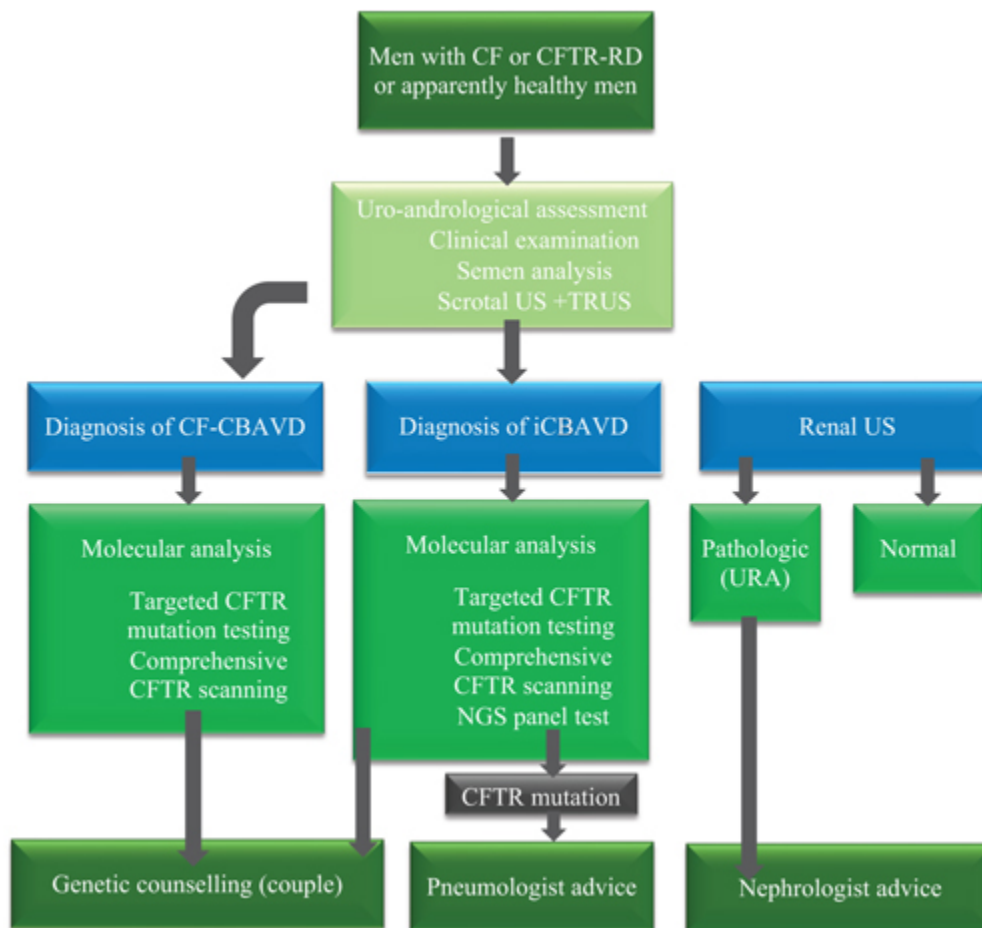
Management of men with congenital bilateral absence of the vas deferens (CBAVD). *Abbreviations:* CFTR, cystic fibrosis conductance regulator gene; iCBAVD, incomplete congenital bilateral absence of vas; US, ultrasound; TRUS, transrectal ultrasound of prostate; NGS: next-generation sequencing. ↩
